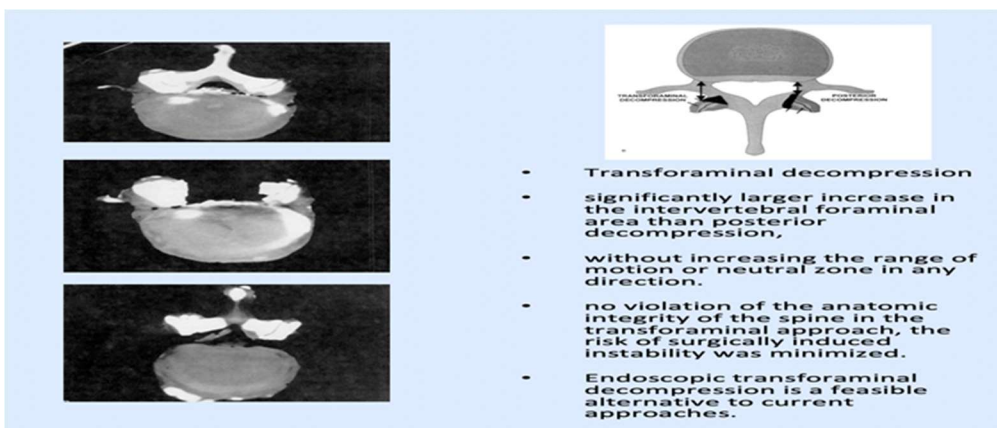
Images above clearly show the fallacy in CT images. The soft tissue in interlaminar window is not relevant to symptom generation. Only subarticular and medial facet face tissue is important.
